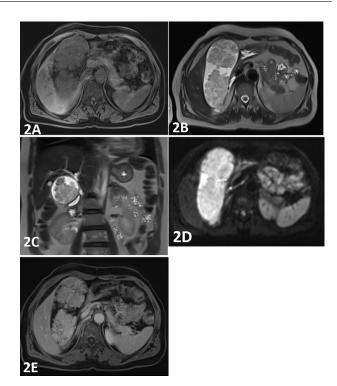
MRI demonstrate the lesions: in hypo signal in axial T1 section (A). An intermediate signal on the T2-weighted sequences in the axial (B) and coronal section (C). A restriction to diffusion image in axial section (D). The lesions do not enhance significantly after administration of Gadolinium in axial section T1 fat sat after injection of gadolinium (E).
